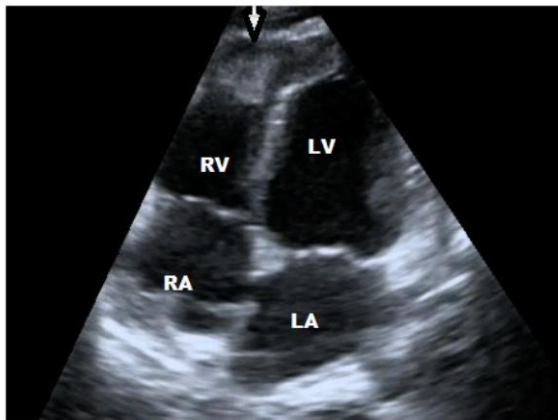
The apical 4-chamber view shows a large (25 x 35 mm) thrombus, originating from the RV apex. LV, Left ventricle; RV Right ventricle; LA left atrium
